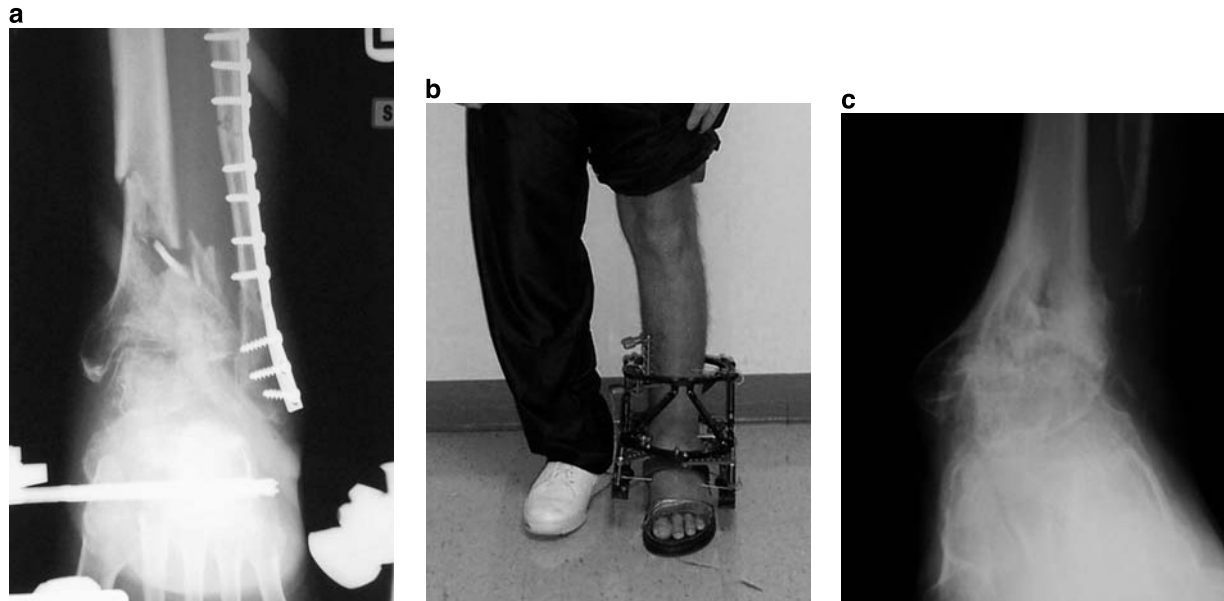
a AP x-ray showing a pilon fracture nonunion 9 months after trauma associated with advanced ankle arthrosis. This patient had been non-weight-bearing in ankle spanning frame for 9 months. b Front standing view showing an Ilizarov/Taylor Spatial Frame being used for simultaneous compression of the plafond nonunion and the ankle arthrodesis. c AP radiograph 9 months after frame removal showing bony union
